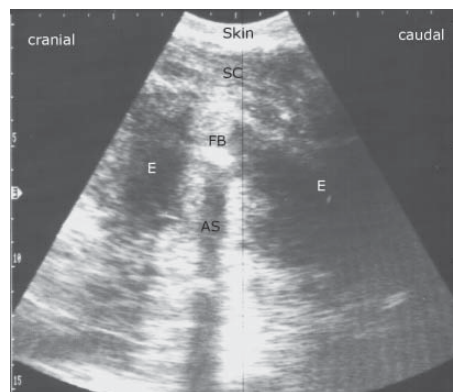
Longitudinal sonogram of the fistula in Fig. 2. The hyperechoic foreign body is surrounded by hypoechoic exudates. Percutaneous exploration confirmed the diagnosis. SC = subcutaneous tissues, FB = foreign body, AS = acoustic shadow, E = exudates.
